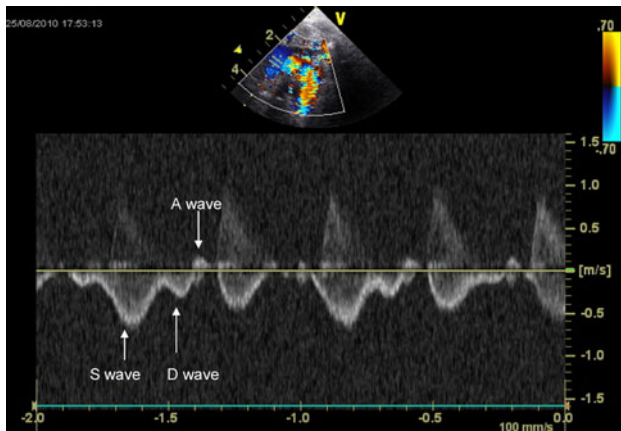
Pulse wave Doppler image showing S, D and A wave traces
